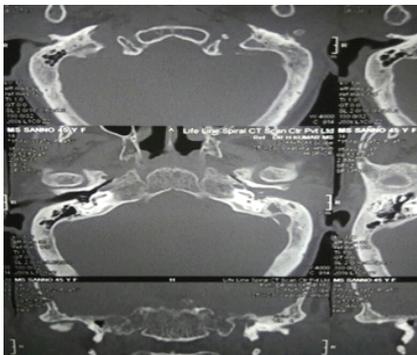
show HRCT finding of left temporal bone.
